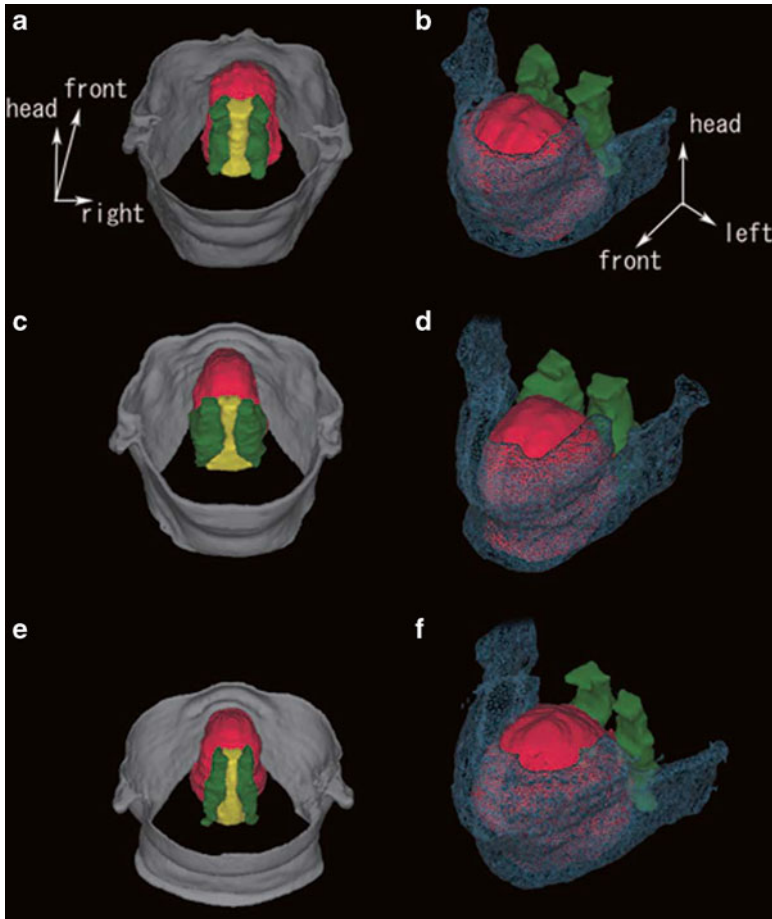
Three-dimensional magnetic resonance imaging reconstructions of subjects with (a, b) positional obstructive sleep apnea syndrome (OSAS), (c, d) non-positional OSAS, and (e, f) control subjects. (a, c, e) Lateral pharyngeal wall, tongue, and pharyngeal airway with outline of the face, posterosuperior view; (b, d, f) lateral pharyngeal wall, tongue, and craniofacial structures (mandible and lower part of maxilla), anterosuperior left oblique view. *Green*, lateral pharyngeal wall; *red*, tongue; *yellow*, upper airway space; and *blue web*, craniofacial structures. Note that positional OSAS had relatively small volume of the lateral pharyngeal wall and smallest craniofacial volume; non-positional OSAS had relatively large craniofacial volume and largest volume of the lateral pharyngeal wall; the control subjects had the largest craniofacial volume and the smallest volume of the lateral pharyngeal wall. (From Saigusa et al. 2009, with permission)
